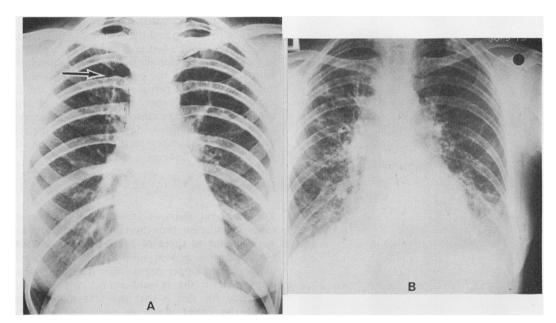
Radiographs of the same patient taken 22 years apart: (A) minimal abnormalities: arrow points to a single tubular shadow; (B) gross abnormalities: tubular shadows in both upper zones, ring shadows in right upper, both middle, and right lower lones, and band-like shadows in right middle and lower zones.
